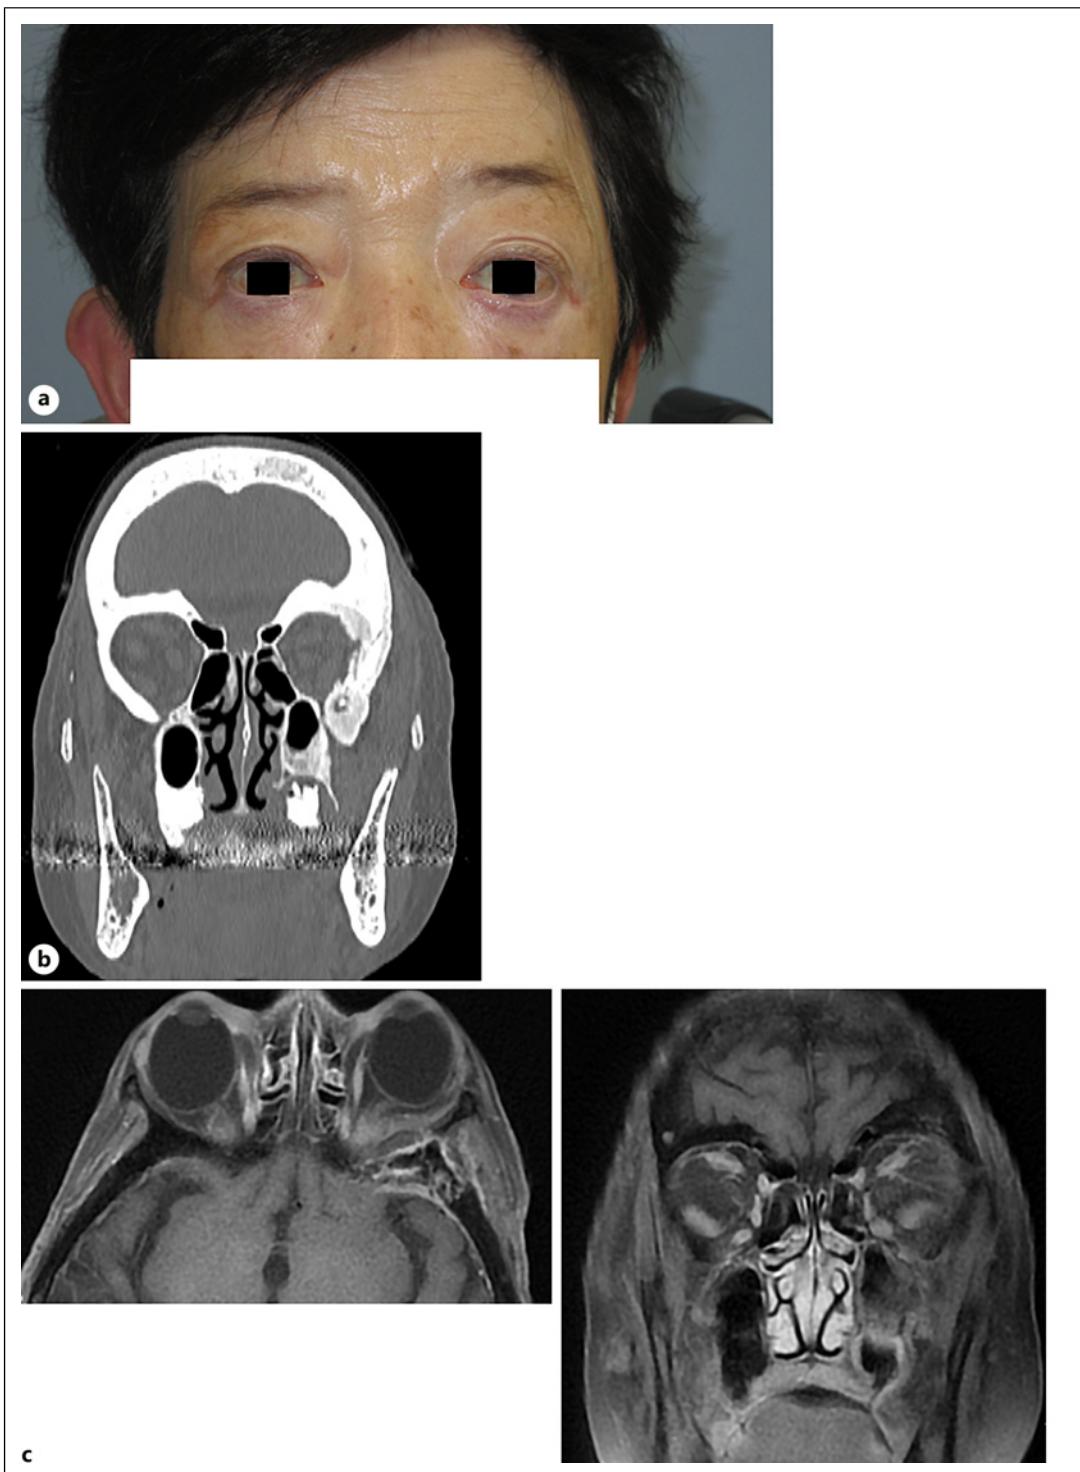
Latest facial photo, simple CT image, and contrast-enhanced MRI image. a Swelling of the left eyelid and temporal region improved. b No progression in bone destruction was observed. c Intraorbital lesion shrank, and abnormal signals in the temporal region improved.
